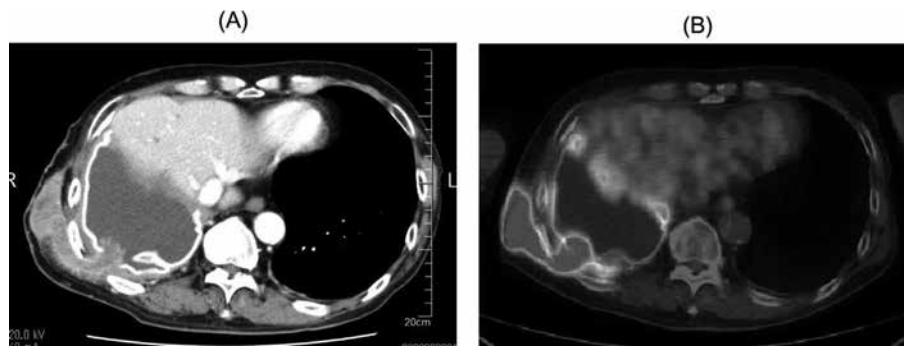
Subcutaneous tumor on the right back of the patient. (A) CT of the chest revealed a tumor of soft-tissue density that expanded from the right pleural cavity into the subcutaneous tissue. (B) 18F-FDG PET-CT showed accumulation of 18F-FDG in the mass.
